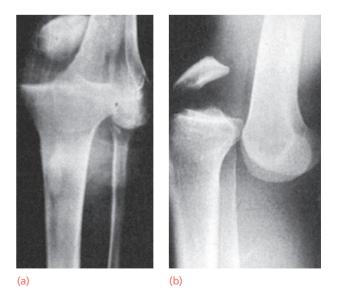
Knee dislocation X-rays showing an anterior dislocation of the knee.
